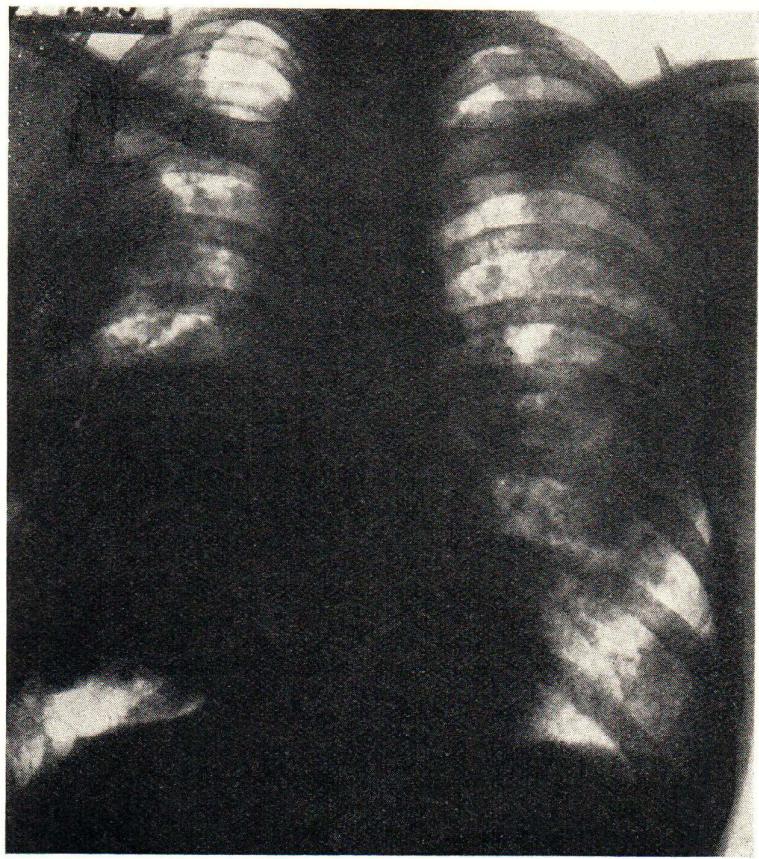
Roentgenogram of the chest of the silicotic whose tracing is shown at fig. 3
